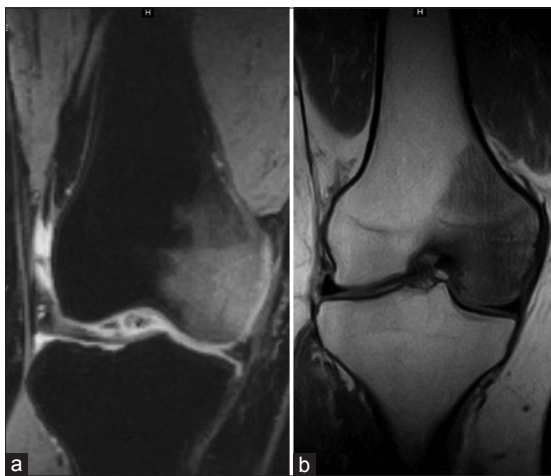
(a) T2-weighted (T2W) fat suppressed coronal image showing medial condylar hyperintense signal changes. (b) T1W coronal image showing medial condylar hypointensity
